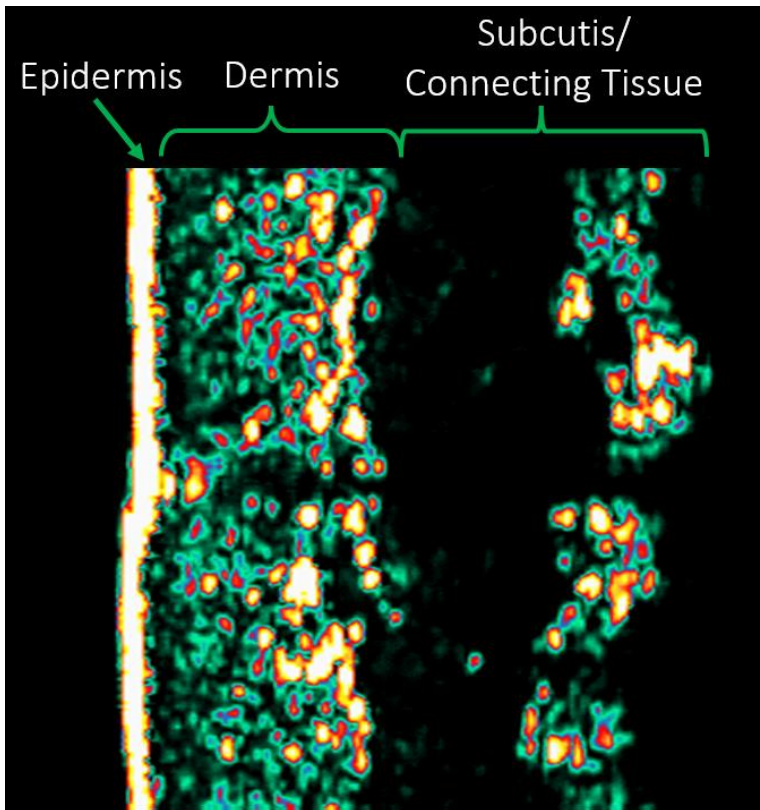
Representative Ultrasound Image with Measurement Areas
